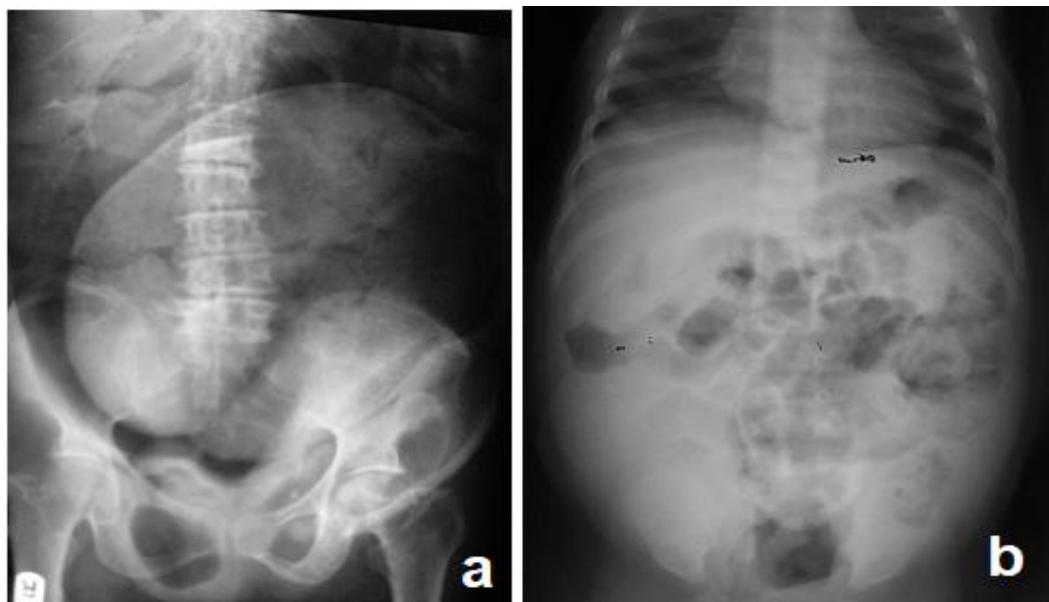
Plain abdominal radiographs. a. Large caecal volvulus with inferior convergence and ahastral bowel with apex above T10 in the left hypochondrium. b. Gross constipation in a child with Hirschsprung's disease.
